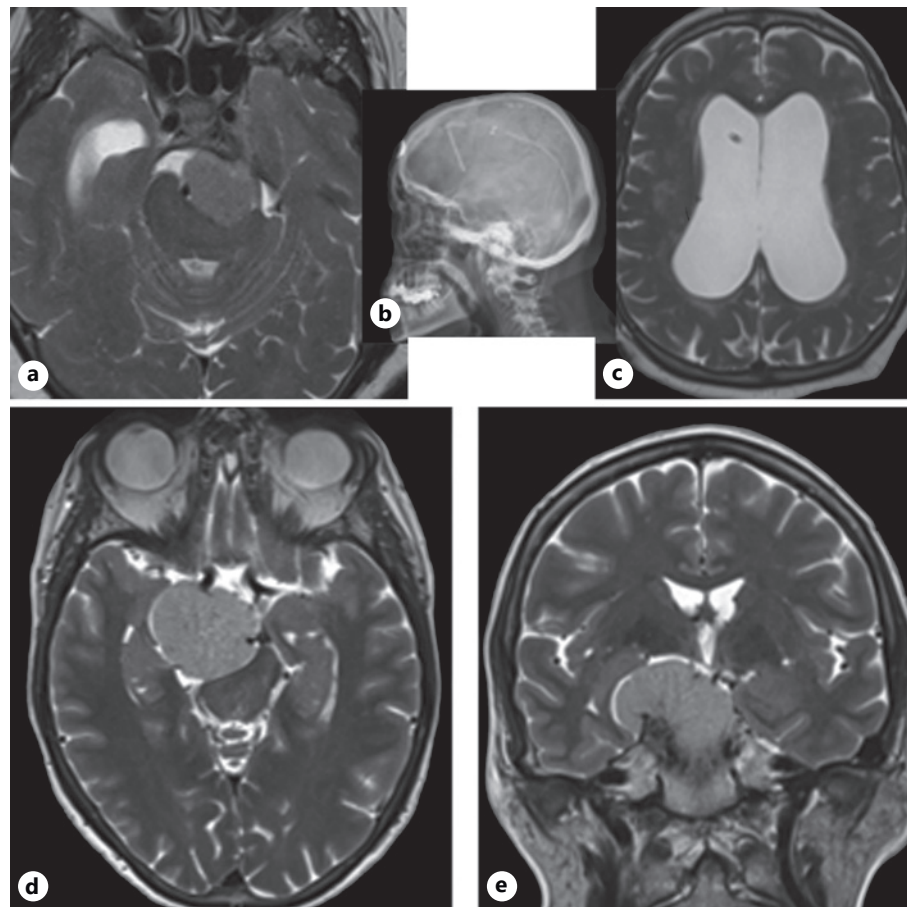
Case-by-case therapeutic strategy: 2 clinical cases. Case 1: 81-year-old woman with petroclival meningioma-inducing hydrocephalus. A ventriculoperitoneal shunt was implanted and meningioma was observed. Axial (a) and coronal (c) T2-weighted MRI and skull X-ray (b). Case 2 (d, e): 57-years-old woman with non-growing and nonsymptomatic petroclival meningioma (observation for 18 months). Axial (d) and coronal (e) T2-weighted MRI.
